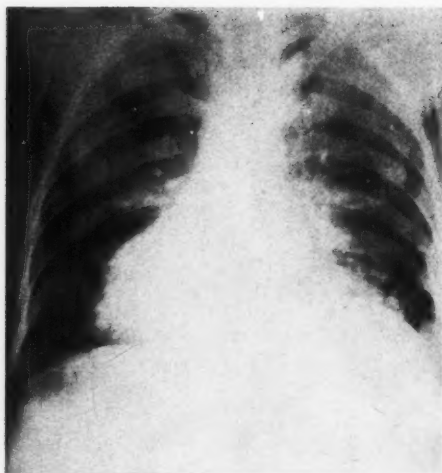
Roentgenogram, Case 1, from which the possibility of a fungus was suggested as the cause of pathology.
